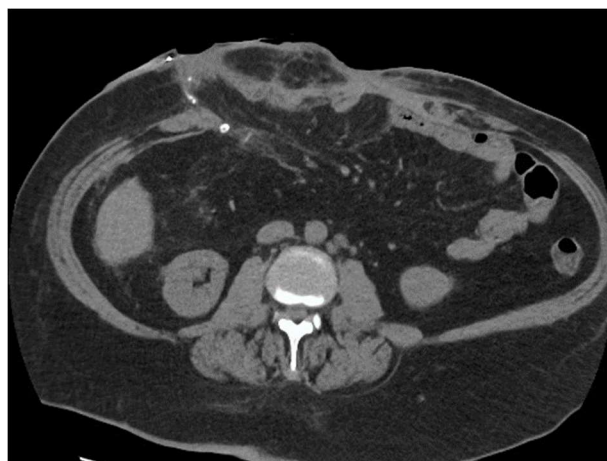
CT scan showing a large ventral hernia
